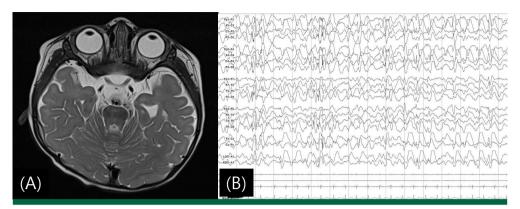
Brain MRI and electroencephalography finding for Patient 2. (A) Normal T2 weighted axial MRI at 8 months of age. (B) EEG showing inconsistent slowing on both frontal areas and frequent generalized polyspikes.
